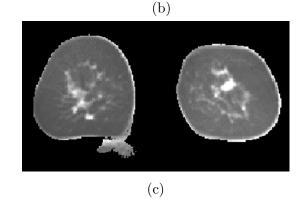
(a) Original MRI breast slices of two different patients. (b) Resulting T_{10} maps with intensity corresponding to T_{10} value magnitude. (c) T_{10} map of another patient produced 5 by the method of Armitage et al. The striking difference in quality of the resulting T_{10} maps is because the method of Armitage et al. suffers from large fitting errors that do not affect our method.
